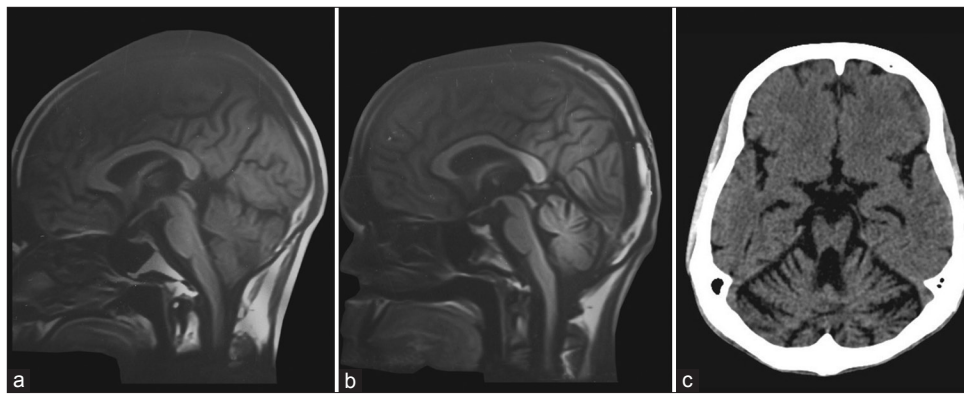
Brain images of II-1 (mild ataxic disease), III-4 (the proband with moderate disease) and III-3 (severe disease) respectively. While (a) (magnetic resonance imaging) shows evidence of mild cerebellar atrophy; (b) (MRI) Shows evidence of moderate cerebellar, and brainstem and upper cervical cord atrophy; (c) (computerized tomographic scan) Shows evidence of gross atrophy of the cerebellum and the brainstem. There is evidence of atrophy of the perisylvian cortex as well
